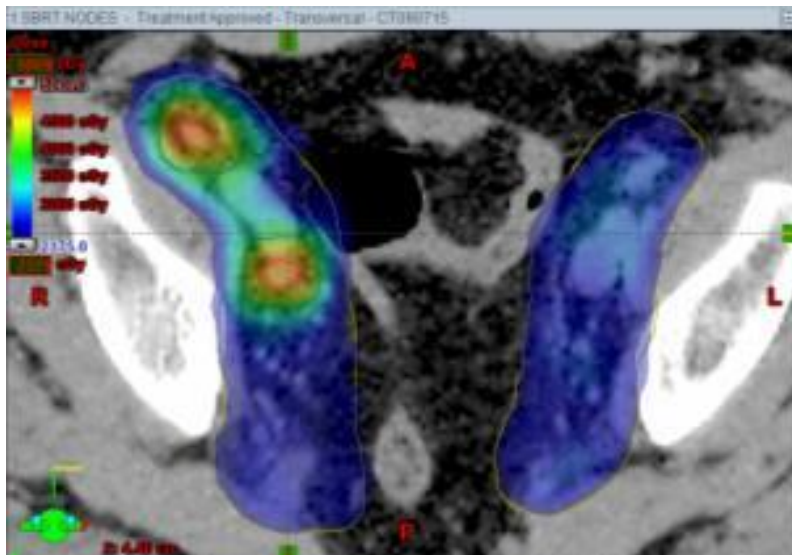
Radiotherapy dose distribution from a SABR treatment of oligometastatic lymph nodes in the pelvis. Note the intense dose in Orange to the PSMA PET avid lymph nodes, and much lower dose in blue to the uninvolved nodes.
